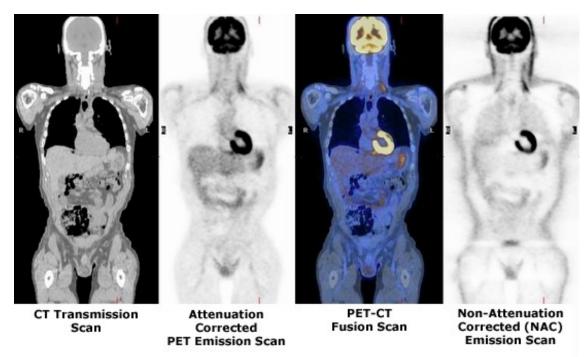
Differences CT, PET, PET-CT images (Med Harvard, 2012)
